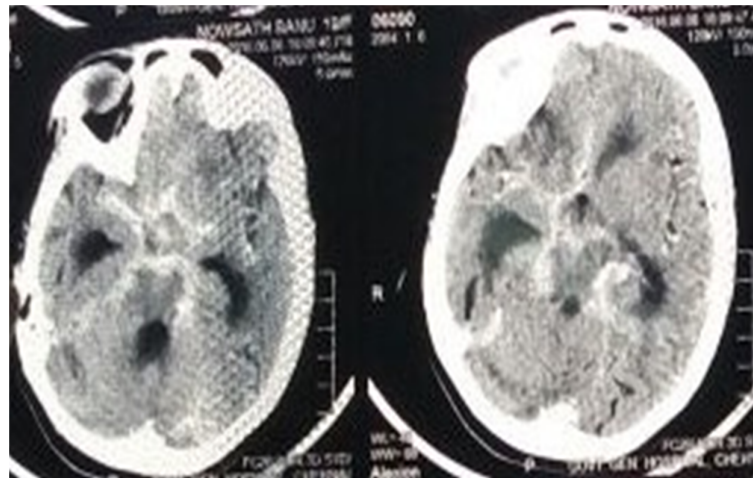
CT Brain contrast showing thick basal exudates.
